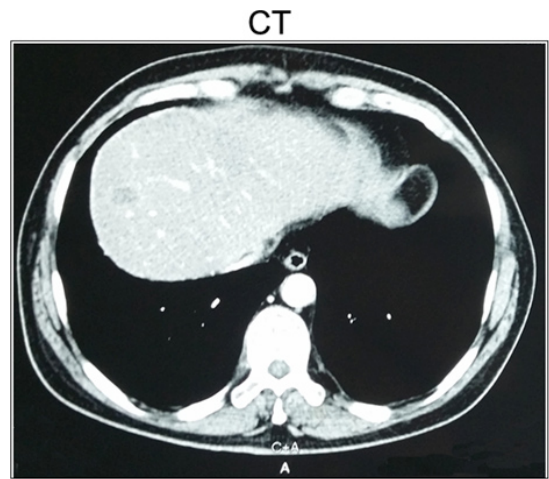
CT after 6-cycle chemotherapy showed a dramatic reduction in the size of the tumor.
